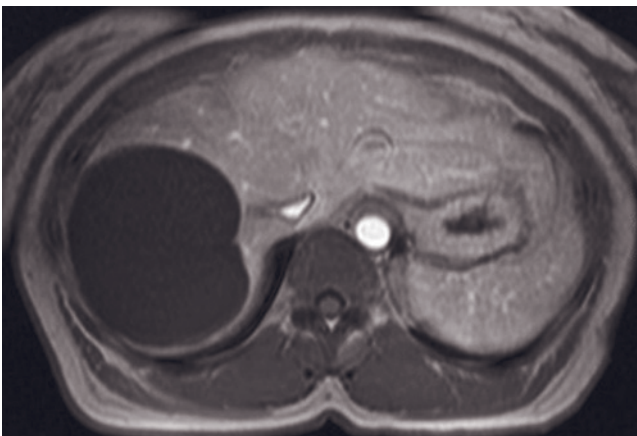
(Continued) on T2-weighted images (arrows, *a*). The 10-mm cyst is signal void on early (*c*) and late (*d*) postgadolinium images.
